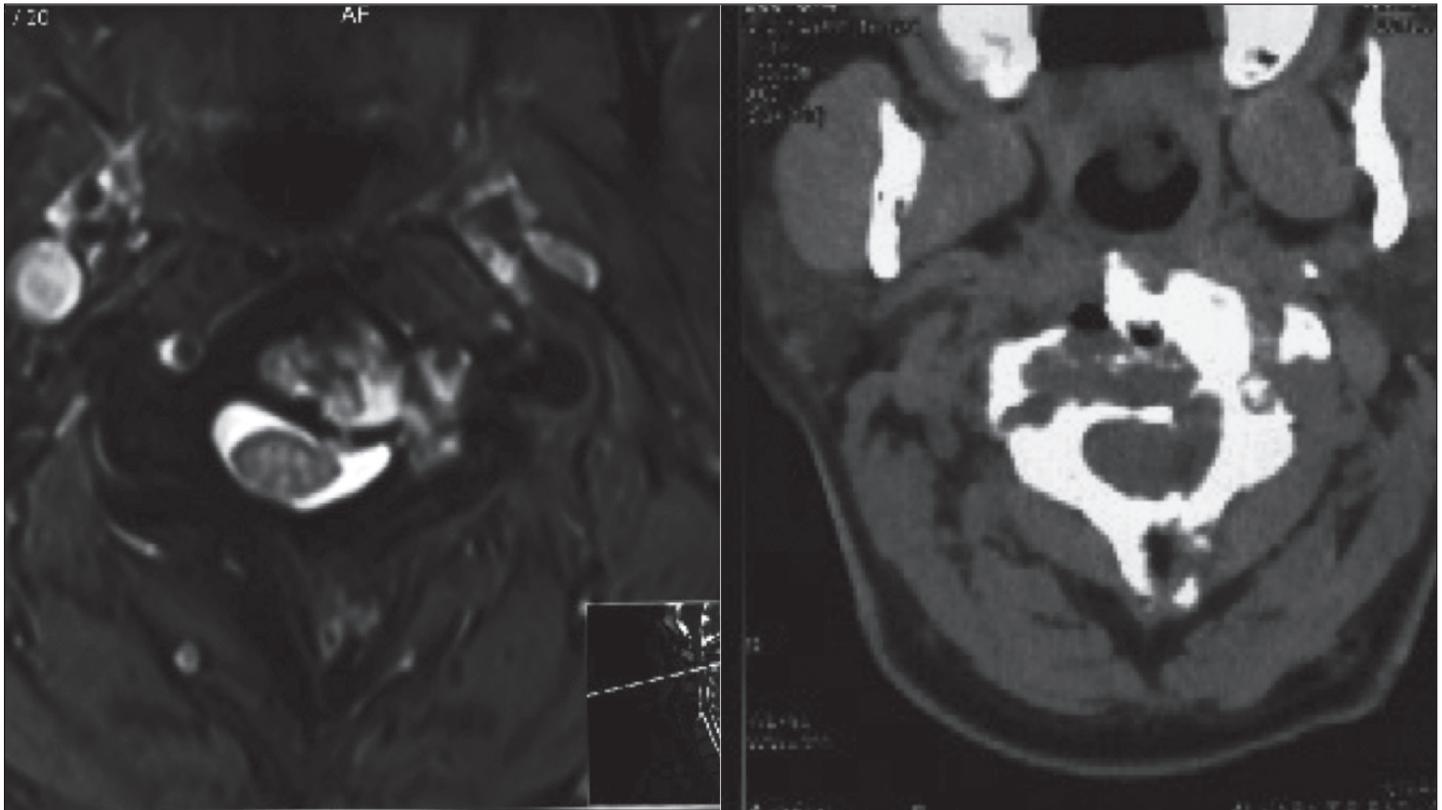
Axial MR image (A) and CT image showing multilobular cyst invading the odontoid process.
